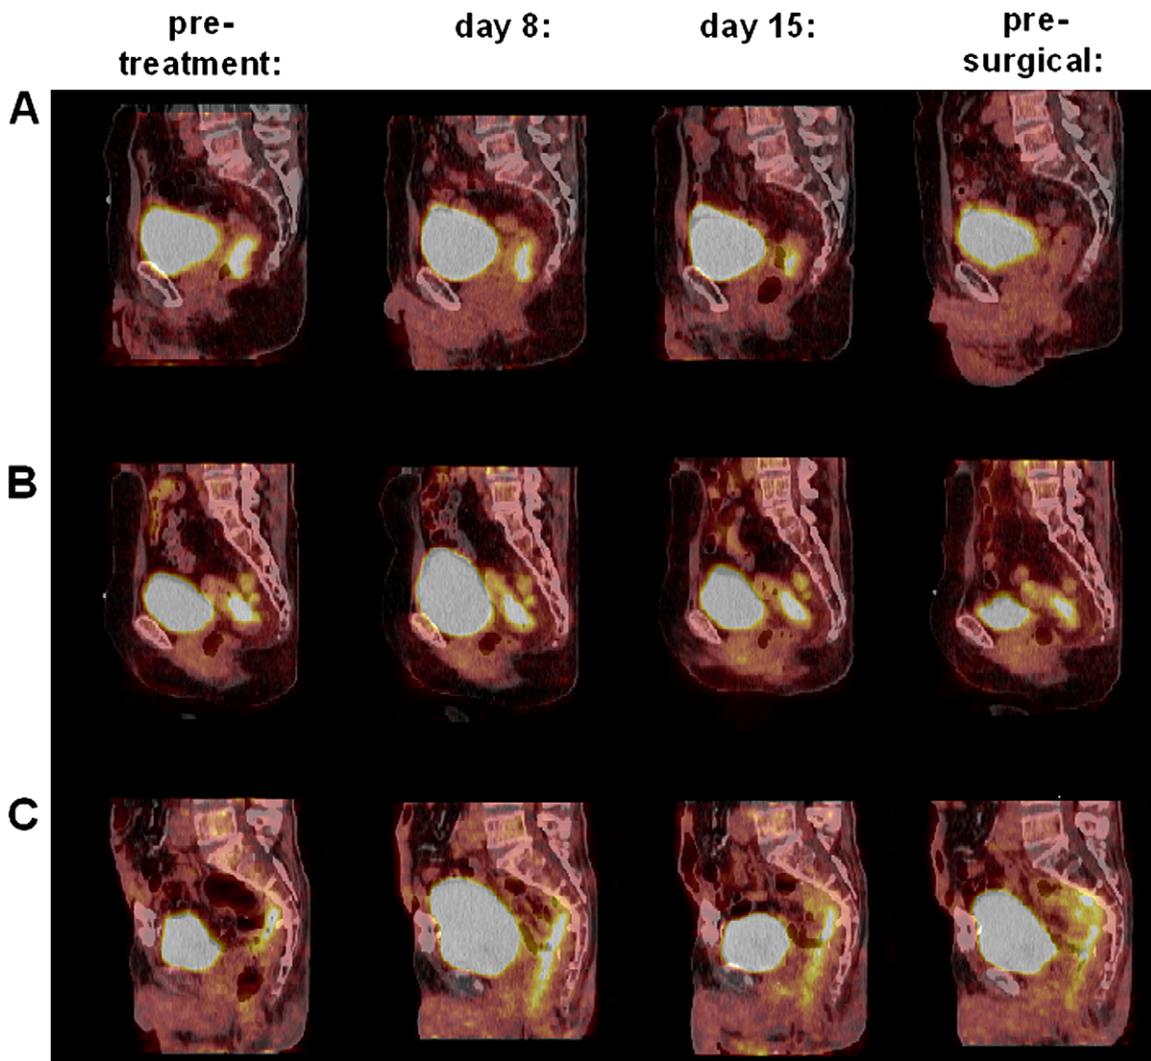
Representative FDG-PET-CT images at all four time points from a complete metabolic responder (A) a non-complete metabolic responder (B) and a patient with a pathological reported peritumoral inflammatory reaction (C).
